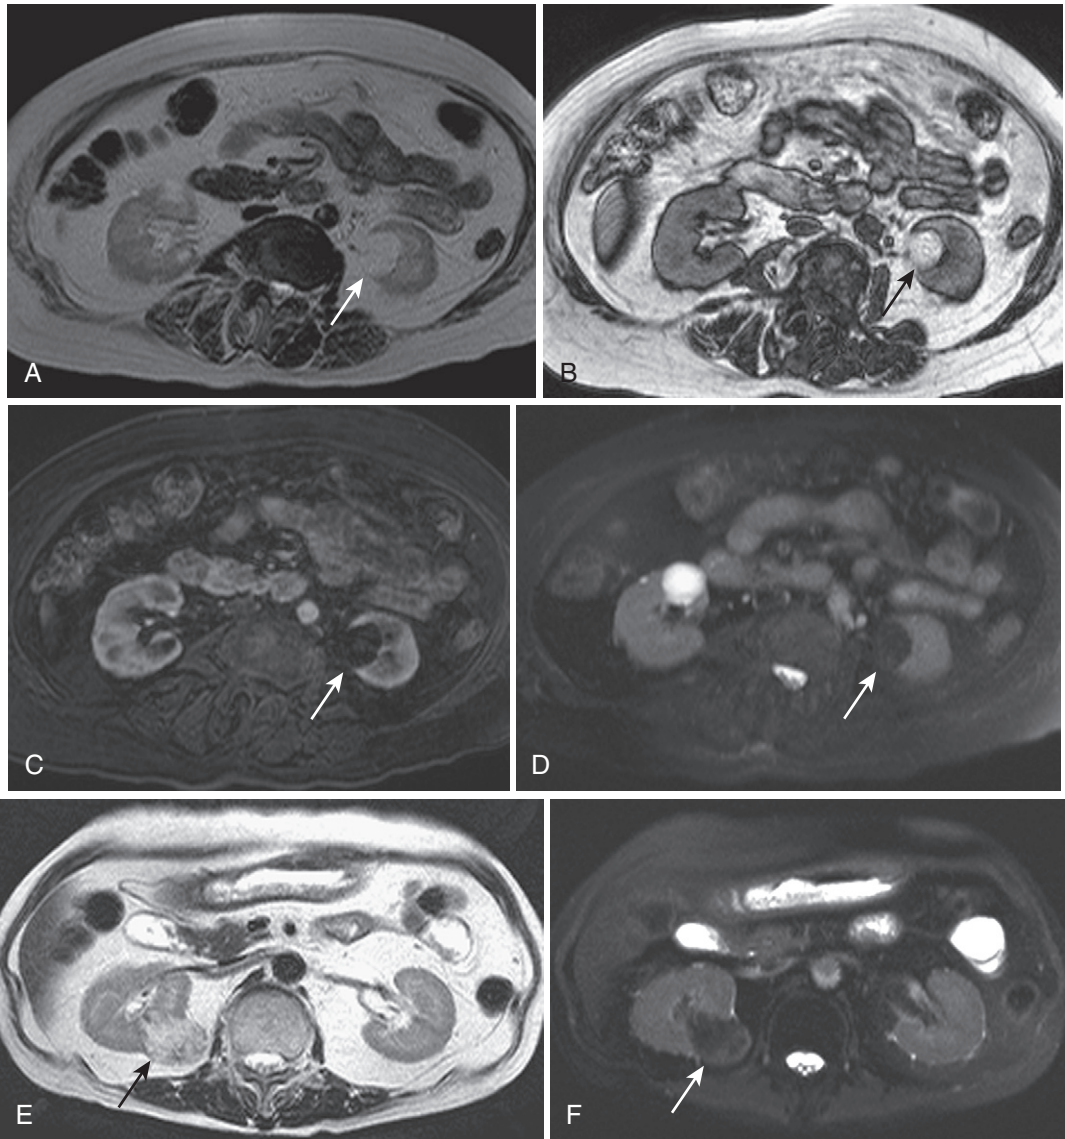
Macroscopic fat in AML. A partially exophytic lesion in the lower pole of the left kidney (*arrow* in A-D) blends imperceptibly with the retroperitoneal fat on the T2-weighted image (A) and on the out-of-phase image (B)—note the phase cancellation artifact at the interface with the water-rich kidney. Complete loss of signal on the fat-suppressed postcontrast (C) and T2-weighted (D) images confirms macroscopic fat. In a different patient, near isointense T2 signal compared with retroperitoneal fat in an exophytic lesion (*arrow*) extending from the lower pole of the right kidney (E) is suppressed on the corresponding T2-weighted fat-saturated image (F).
